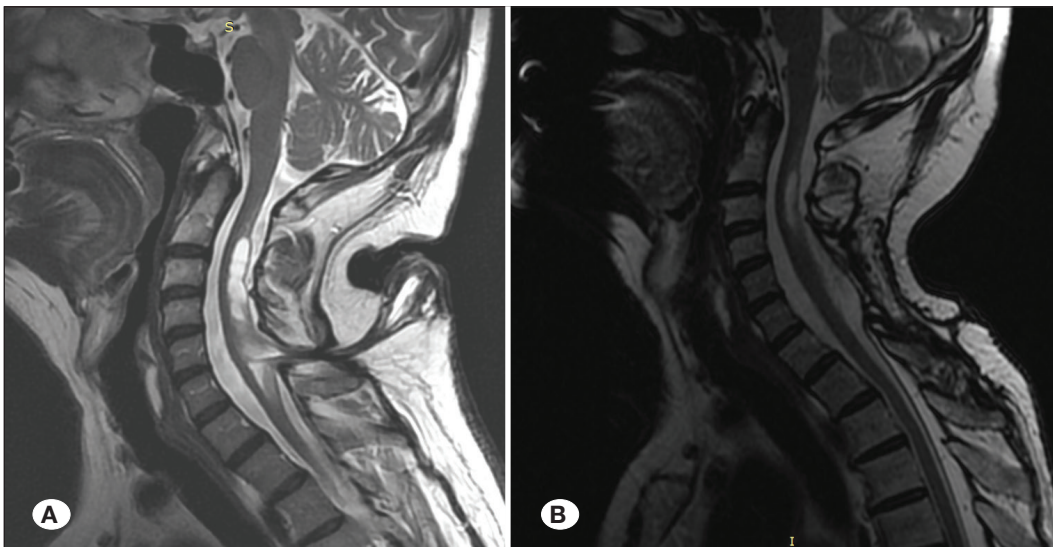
Cervical sagittal T2-weighted MRI. A) Pre-operative. Note the syrinx cavity and the tethering meningocele at the C6 level. B) Post-operative. Significant resolution of the syrinx cavity with detethered spinal cord.
